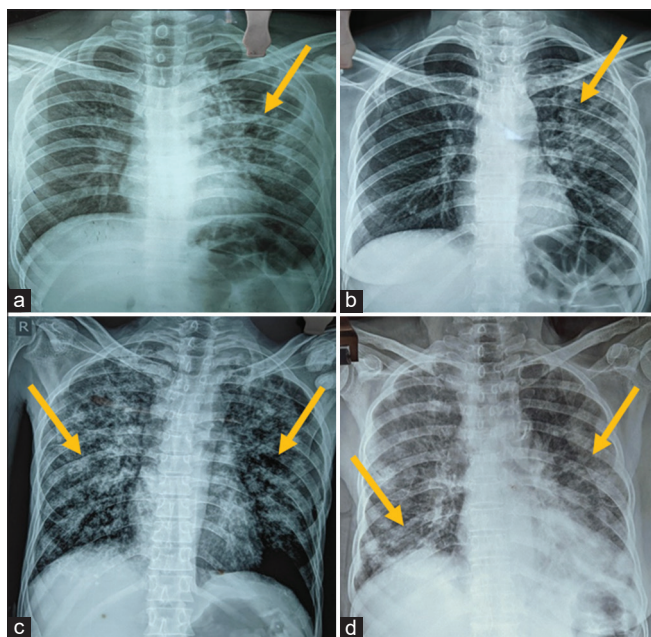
Chest X-ray postero-anterior view of four patients with pulmonary tuberculosis (lesions shown by yellow arrows). (a) and (b) are radiographs of patients who had negative sputum acid-fast bacillus showing predominantly upper and mid-zone unilateral infiltrates on the left lung. (c) and (d) radiographs show extensive bilateral infiltrates of patients who had 3+sputum acid-fast bacillus positivity
